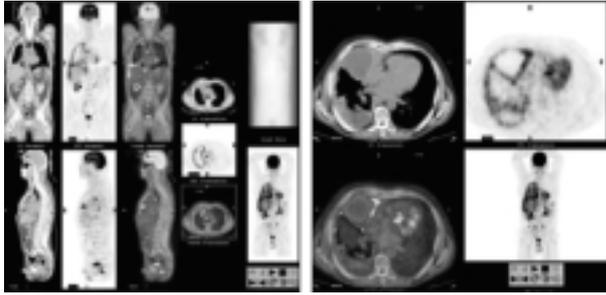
A 62-year-old man with a malignant pleural mesothelioma of the right lung. (A) Full computer screen with CT, PET, PET/CT scans and maximal intensity projection (MIP) showing the extent of disease. No evidence for extrathoracic metastases. (B) Transaxial CT, PET, and PET/CT scans showing diffuse pleural thickening. Some lesions do not accumulate FDG, demonstrating inactive pleural fibrosis.
